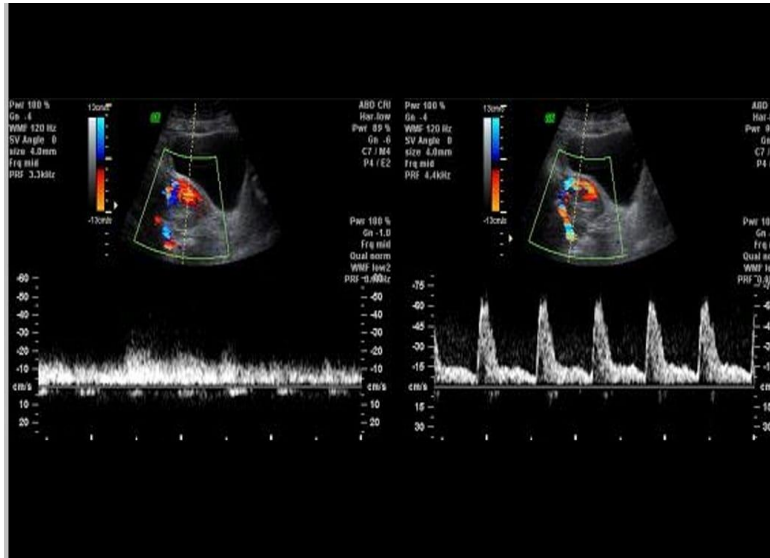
Spectral Doppler ultrasonography reveals uterine arteries flowed in a low-resistance pattern and venous flow is seen by spectral tracing in the draining veins.
